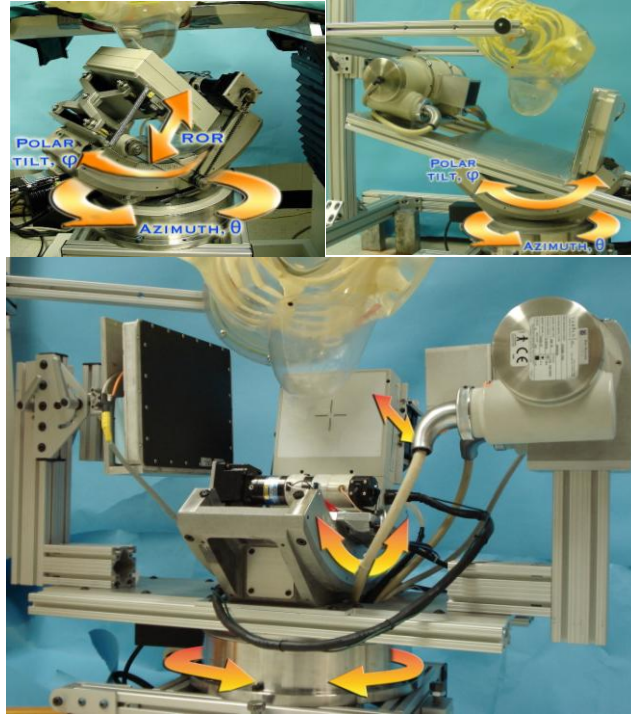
Photographs of the (TOP LEFT) individual SPECT and (TOP RIGHT) CT imaging systems and (BOTTOM) the integrated dual-modality system. Orange arrows indicate direction of sub-system movement. The SPECT system is capable of full 3-D motion in a hemispherical space, and the independent CT system is individually capable of 3-D motion, but in the combined, hybrid system, the CT sub-system is restricted solely to azimuthal motion.
